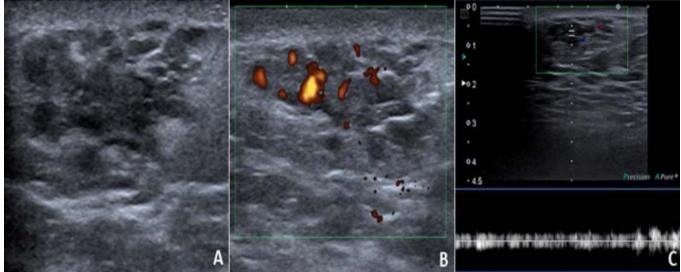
(A, B, C): Ultrasound images depicting an irregular hetero-echoic mass with indistinct margins in the superficial plane of the left breast showing vascularity within with a venous pattern.
